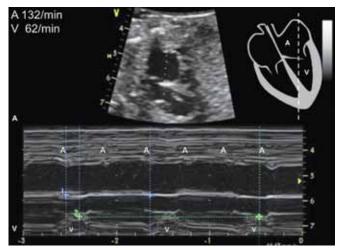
M-mode Doppler shows fetal complete atrioventricular block in a baby with positive maternal anti-LA/Ro autoantibodies
